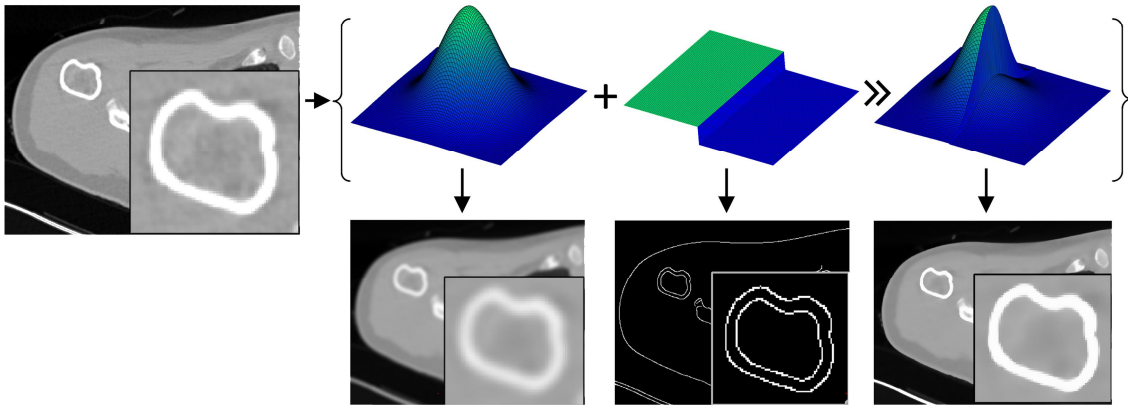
Bilateral noise removal filter applied to a slice of CT scan data of a shoulder joint.
